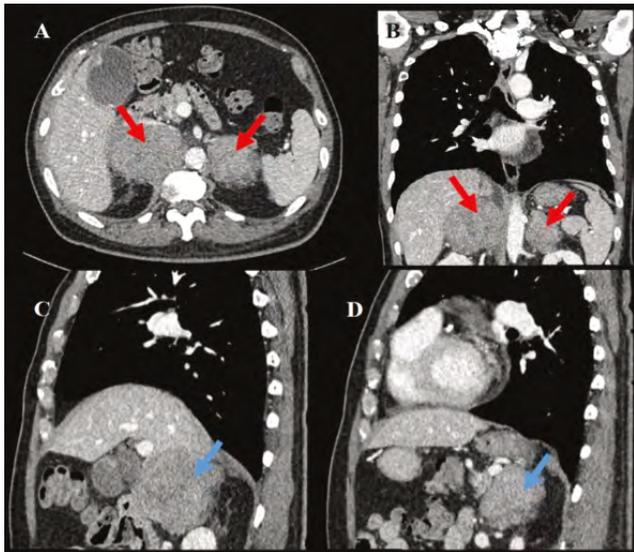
Axial (A), coronal (B) slices of contrasted abdominal CT scan showing large enhancing bilateral adrenal masses (red arrow). Subsequent images (C) and (D) show sagittal images of right and left adrenal masses respectively (blue arrow).
